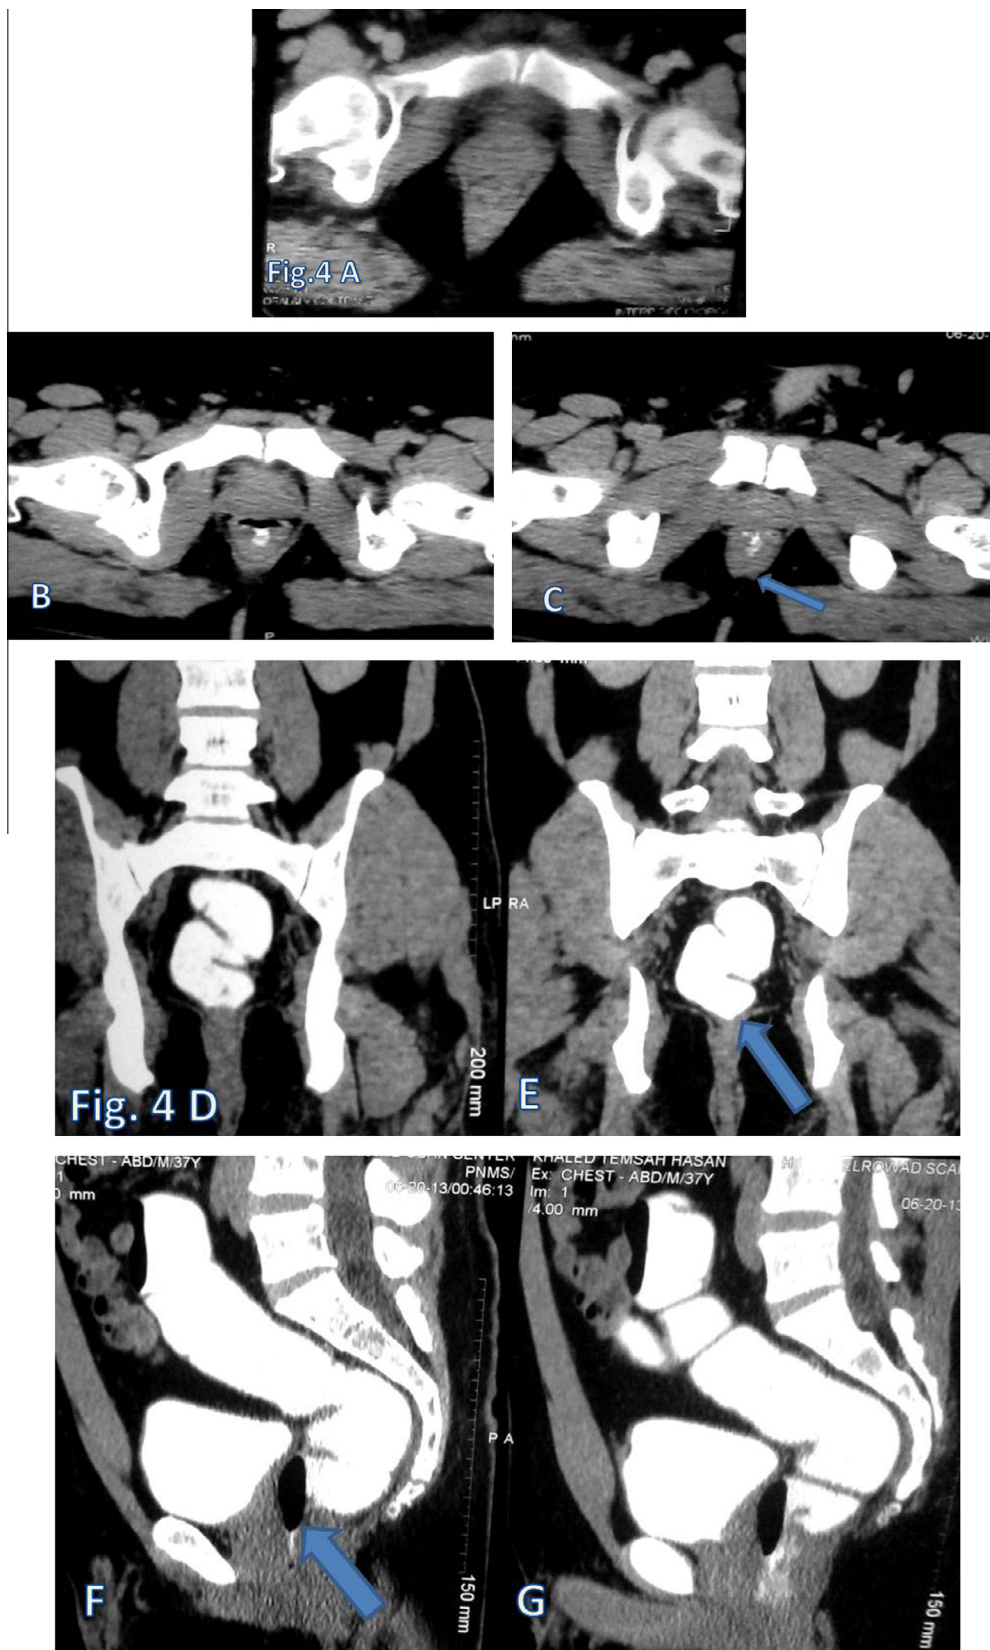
38 year old male patient: Axial CT, MPR image (A) with oral contrast only, no definite rectal lesion identified. After endorectal contrast (B & C) no significant lesion could be identified, only, minute focal bulge on Lt. postero-lateral wall (opposite 5 O'clock position), with preserved related peri-rectal fat planes (arrow on C). On coronal cuts after endorectal contrast (D & E), there is abrupt cutting to contrast at the distal rectal region with significant proximal shouldering (arrow on E) and this could not be detected on axial images. On sagittal MPR image after endorectal contrast (F & G), the mucosal destruction and irregularity appeared clearly with preserved peri-rectal fat planes and proximal shouldering (arrow on F).
